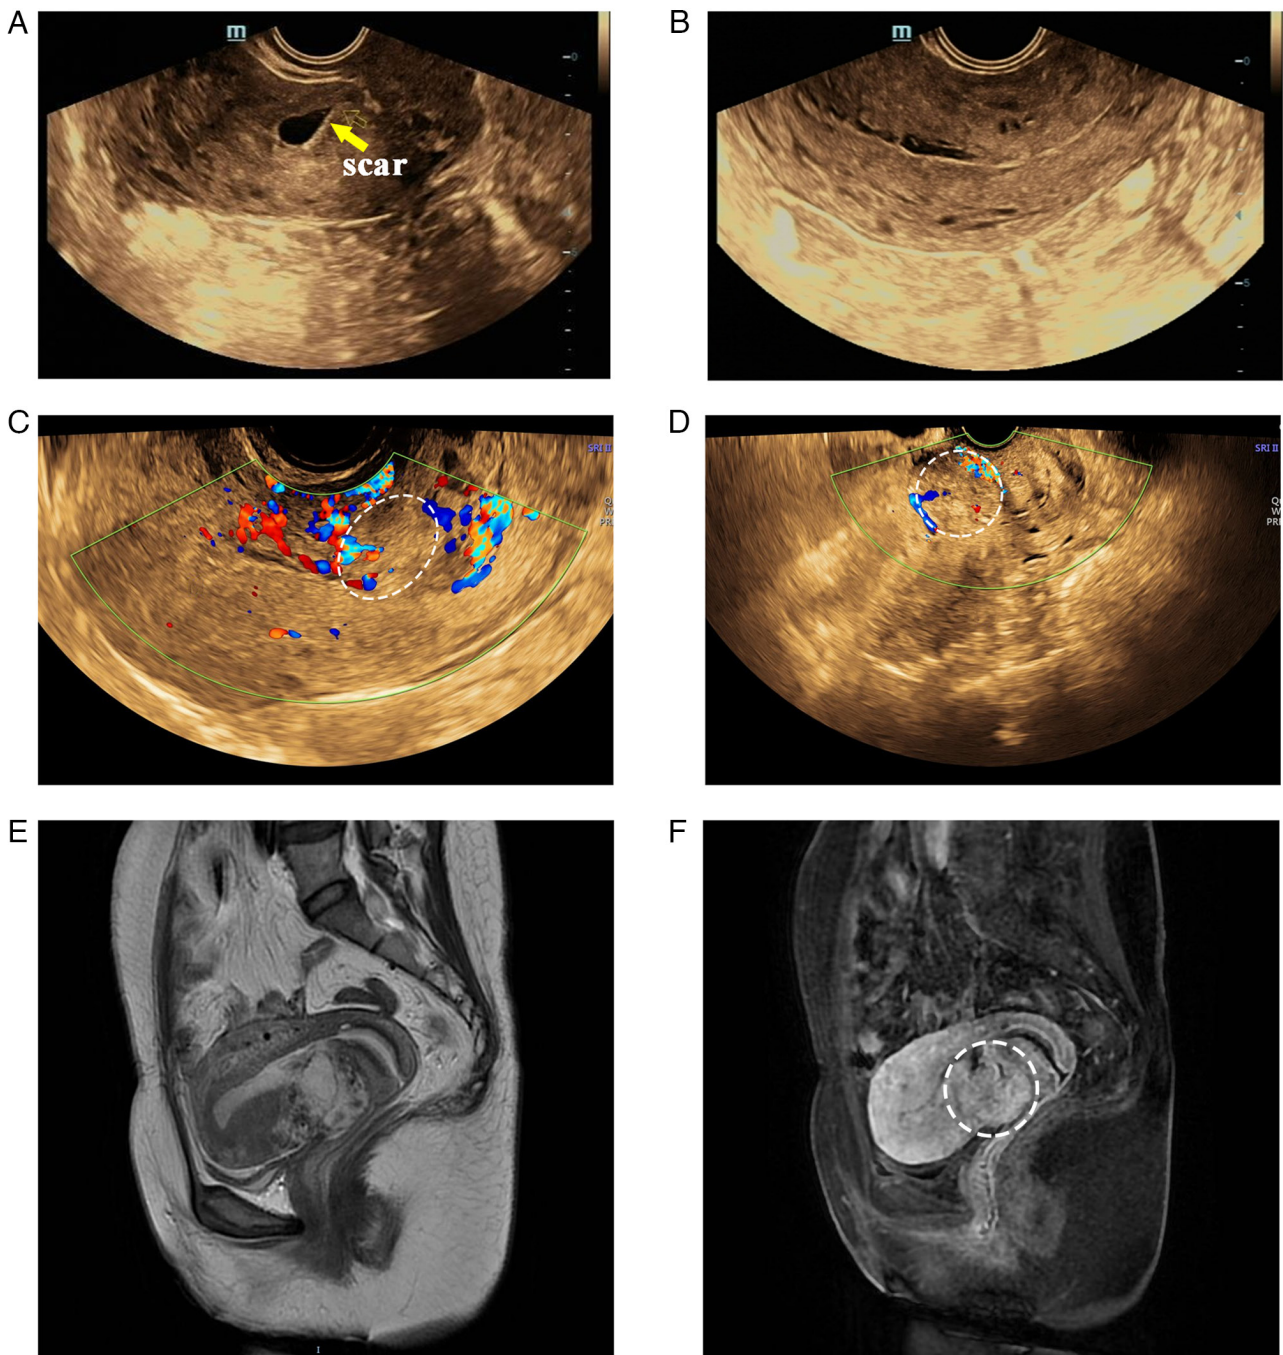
Imaging results. Ultrasonographic exam showing (A) a cesarean scar (yellow arrow) before the operation; (B) a widened uterine cavity in the lower segment at 24 days postoperatively; (C) a heterogeneous mass (dashed circle) and hypervascularity at 51 days postoperatively; (D) a shrunk lesion with reduced blood flow after three methotrexate treatments; (E) T1-weighted and (F) T2-weighted pelvic MRI confirming that the mass was 4.0x4.4x4.0 cm (white arrow) at 51 days postoperatively. MRI, magnetic resonance imaging.
